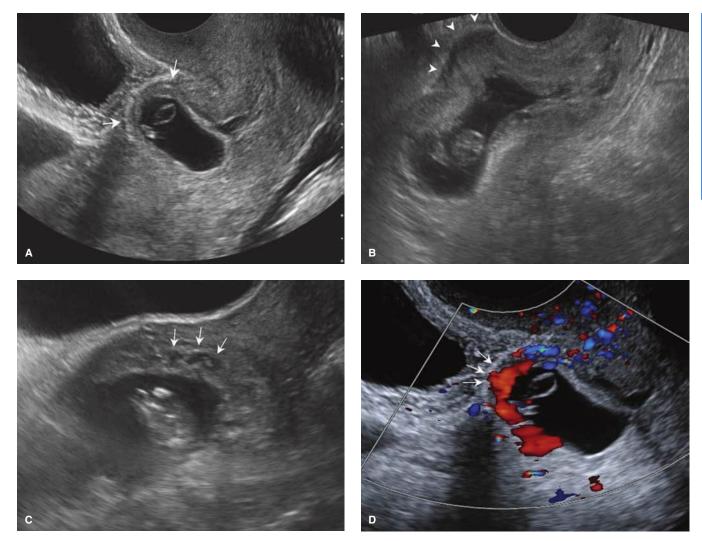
Cesarean scar pregnancy, transvaginal images. A. The trophoblast appears to fill the scar "niche" (*arrows*). B. Outward bulging of the gestational sac toward the bladder (*arrowheads*). C. Placental sonolucencies (*arrows*). D. Attenuation of the retroplacental myometrium. The distance from the anterior trophoblastic border to the uterine serosa is <1 mm (*arrows*). Color Doppler demonstrates vascularity in the region of the prior hysterotomy scar.
